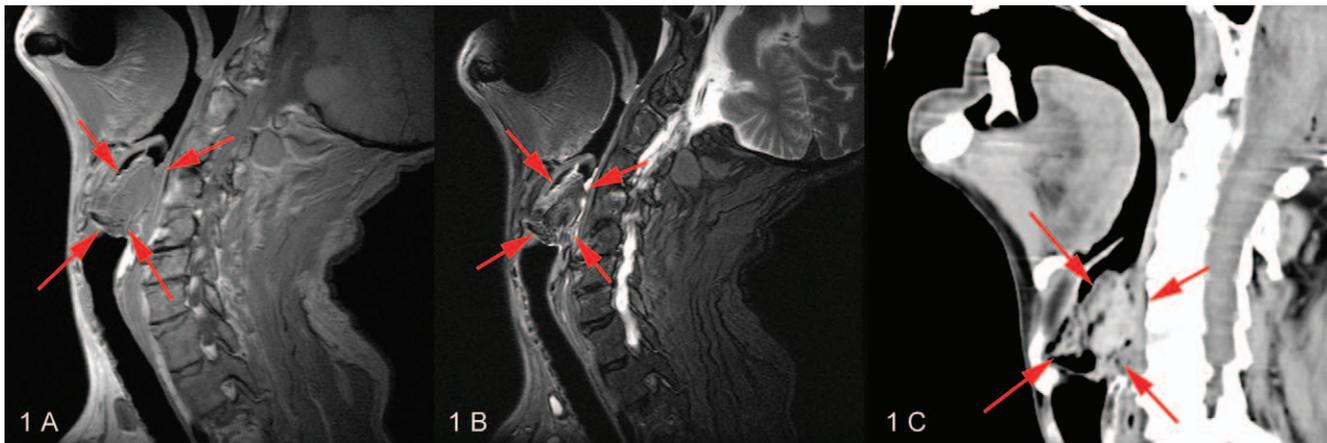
Sagittal cross sections on the midline of the neck. Corpus alienum in the larynx (red arrows). A, T1-weighted magnetic resonance imaging. B, T2-weighted magnetic resonance imaging. C, Multiplanar reformation of multislice computed tomography data.
